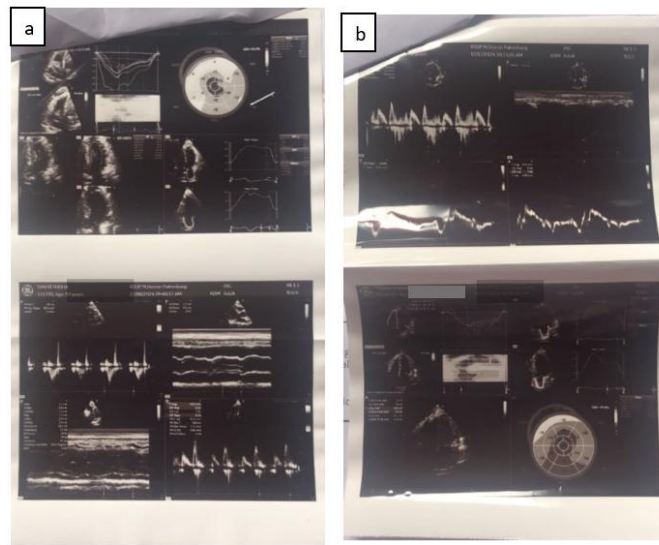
Patient's echocardiogram results
